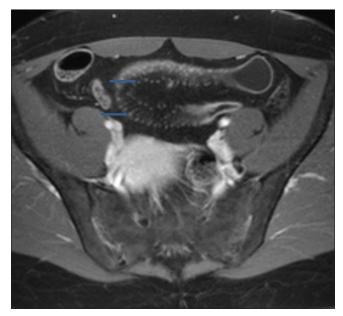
Axial postcontrast T1-weighted image shows the "comb sign" (arrows) with vascular engorgement in the mesentery, a finding suggestive of active disease
